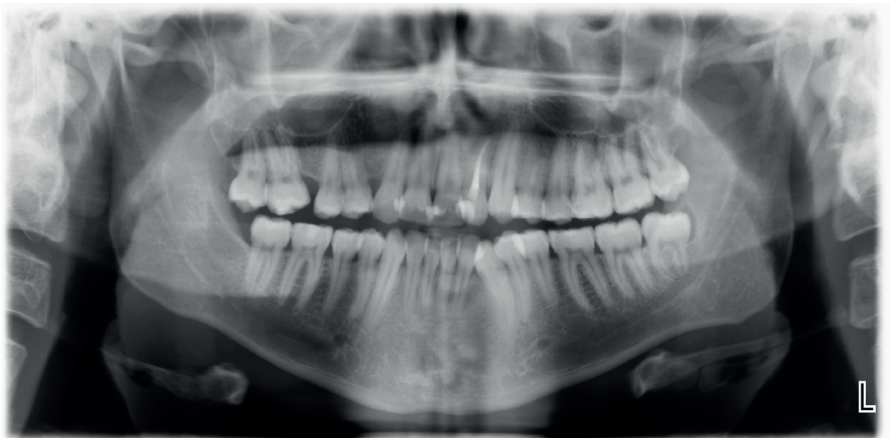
Panoramic Radiography
